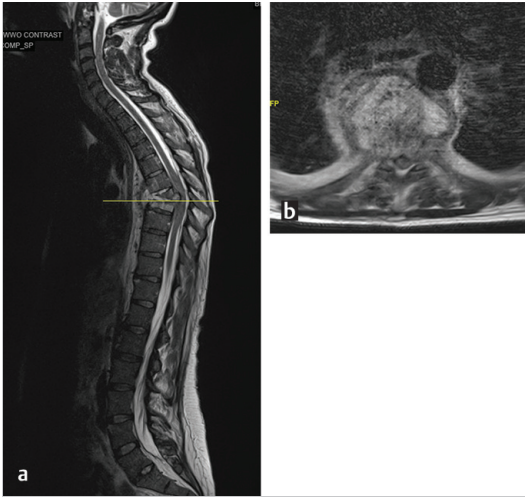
Sagittal (a) and axial (b) T2-weighted images of the entire spine demonstrating focal kyphotic deformity in the setting of T7 and T8 vertebral bodies collapse.
